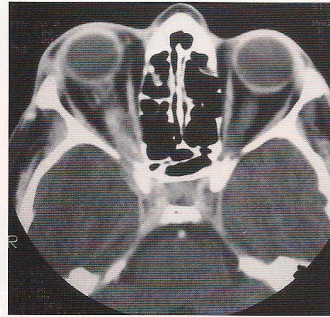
Axial computed tomography showing meningeoma of the right optic nerve sheath.
